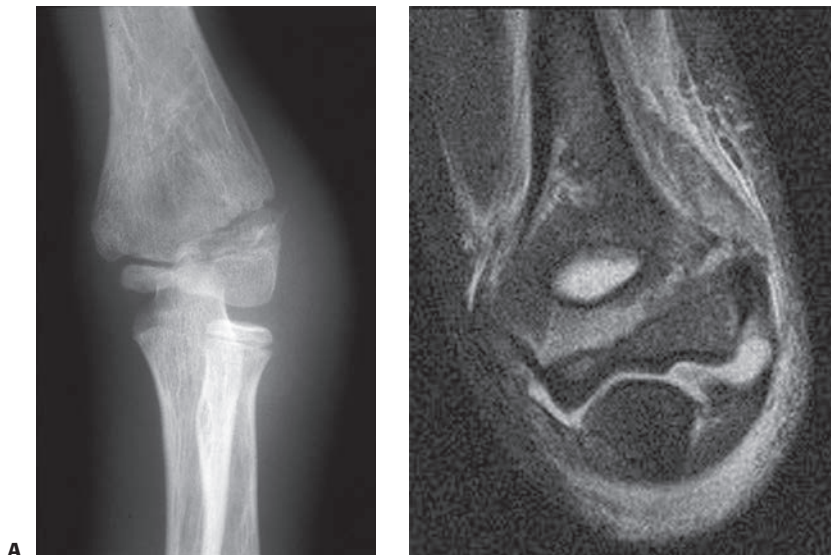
A: Radiograph of what appears to be a stable type II fracture of the lateral condyle in a 10-year-old child. B: Gradient-echo MRI clearly shows that this is a fracture of the entire distal humeral physis.
